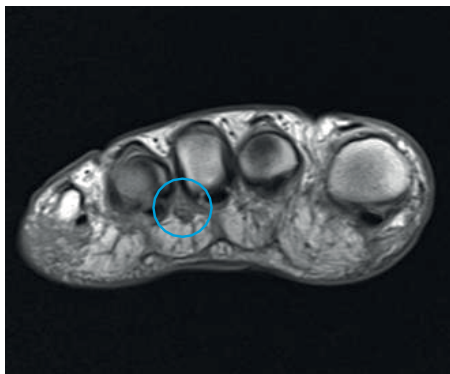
MRI with Morton's neuroma
